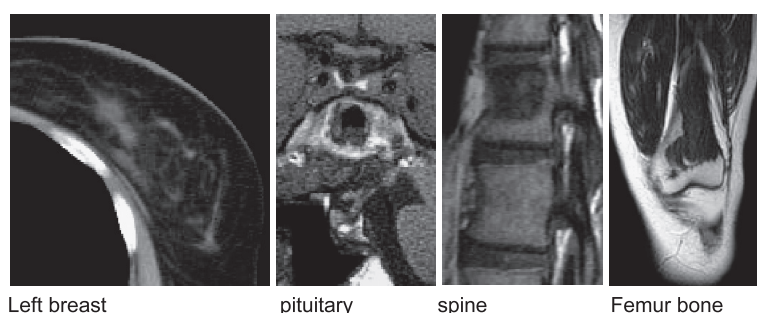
Photographs of MR and CT imaging before (A) and after (B) glucocorticoid treatment for ECD. CT imaging of the left breast shows a significant reduction in xanthogranulomas after glucocorticoid treatment (left panels). MR imaging of the pituitary (T1-weighted coronal and sagittal), spine (T1-weighted sagittal), and femur bone (T2-weighted coronal) shows no progression of the xanthogranulomas following glucocorticoid treatment. Note that the patient had transsphenoidal surgery for removing a pituitary mass and glucocorticoid administration for bronchial asthma before the current glucocorticoid treatment.
